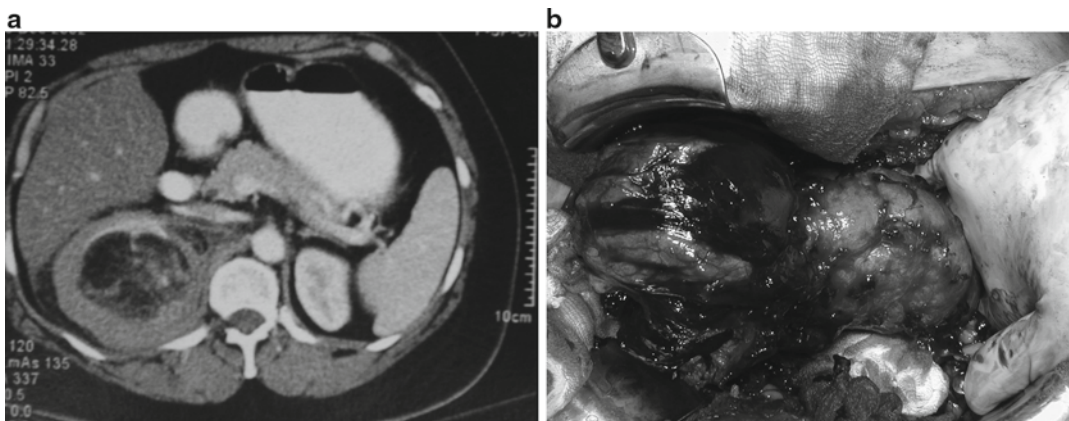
(a) CT scan shows large angiomyolipoma of the right kidney with associated perirenal hematoma. (b) Intraoperative appearance of same angiomyolipoma showing upper pole lesion with hemorrhage
